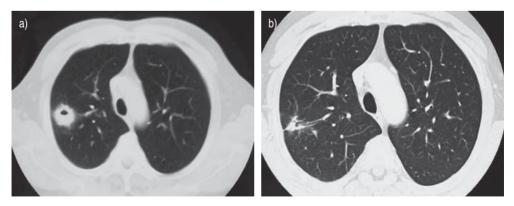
a) Computed tomography scan of a nodule (2.3 cm) with spiculated margins and eccentric cavitation with thick walls of the right upper lobe. Transbronchial needle aspiration showed purulent material with identification of *Staphylococcus aureus* (abscess). b) A computed tomography scan showing regression of the lesion after 15 days of antibiotic therapy.
